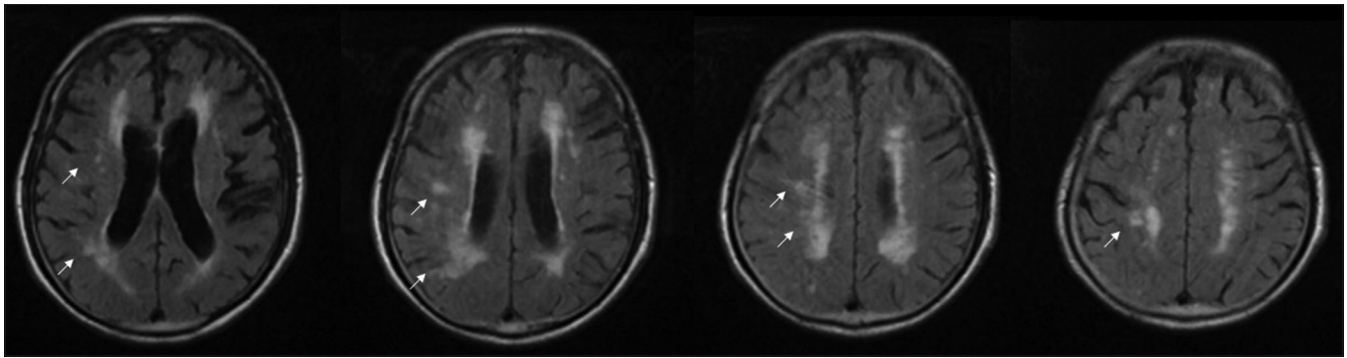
Fluid-attenuated inversion recovery images. A pale hyperintense lesion appeared in the area that showed hyperintense signal on DWI and was considered to be multiple subacute strokes (indicated by white arrows). DWI: Diffusion-weighted image
